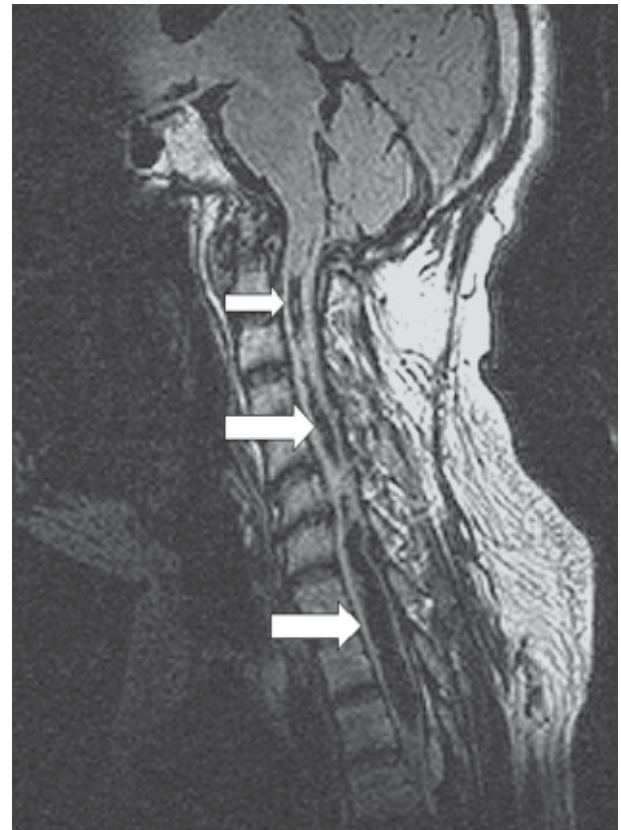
Magnetic resonance sagittal T1-weighted image showing the syrinx cavity that extended from C2 to T6 level of the spinal cord.
